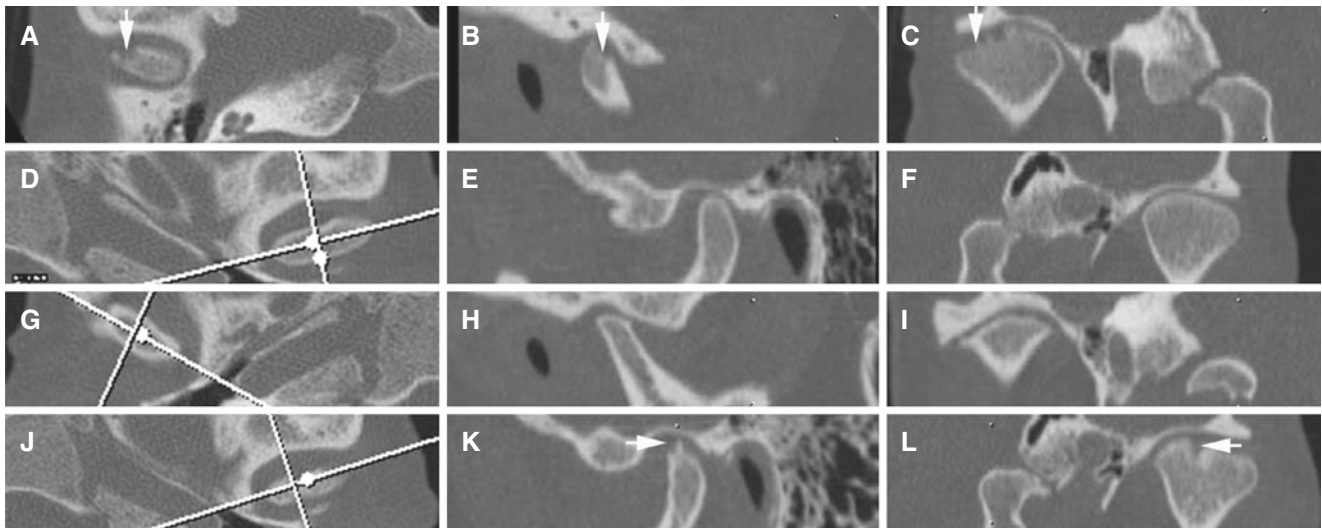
Osteoarthritis, with 5-year follow-up: “improvement” in one joint, progression in contralateral joint; female 36-year-old at baseline (A–F). (A) Axial, (B) oblique sagittal, and (C) oblique coronal CT images of the right joint show cortical erosion in lateral part of the condyle (*arrow*). (D) Axial CT (with *cursor lines*), (E) oblique sagittal, and (F) oblique coronal CT images of the left joint show normal bone. At 5-year follow-up (G–L), (G) axial CT (with *cursor lines*), (H) oblique
